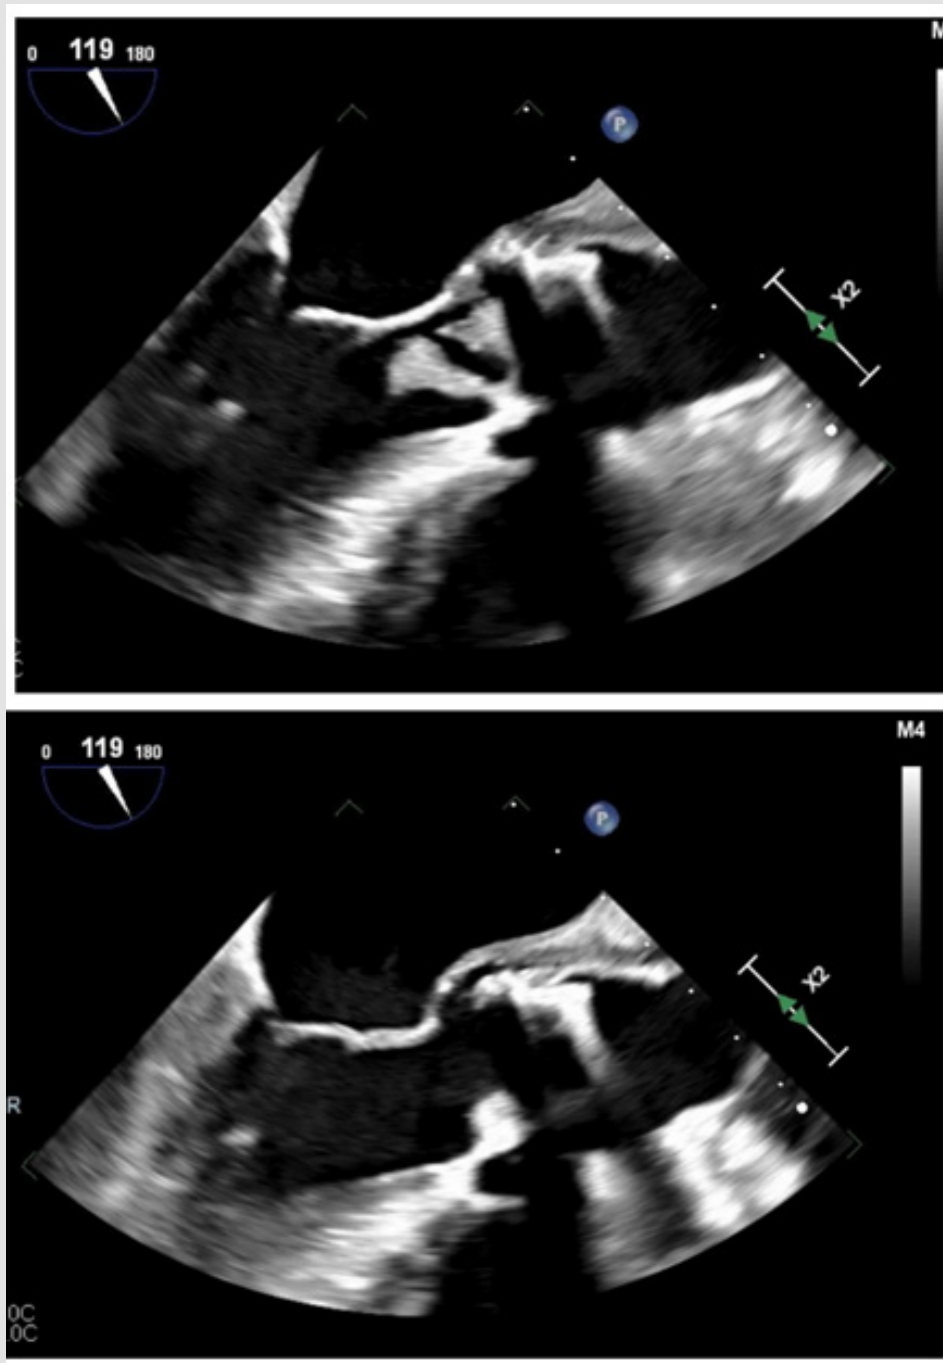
Transesophageal echocardiogram images showing valve dehiscence and fistula
